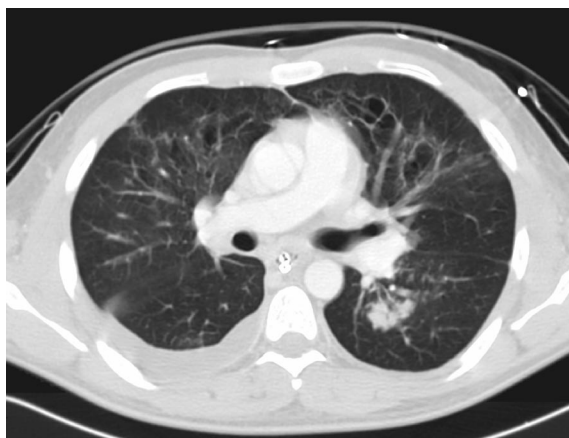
Initial computed tomography scan, 7 days after injury—case 4.
